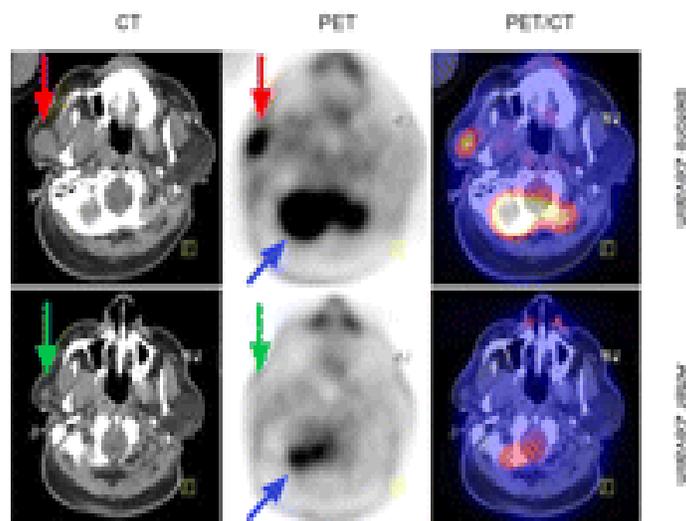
Partial response by CT scan of the mass in right parotid region, with complete response by PET, with significant reduction of SUV from 6.3 to 1.2.
